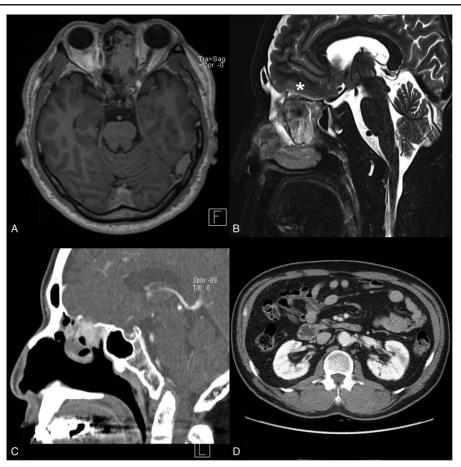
Radiological findings. Preoperative T1-weighted axial MRI with gadolinium enhancement (A) and T2-weighted sagittal MRI (B) demonstrated a heterogeneously enhanced mass in the paranasal sinus with invasion of the dura mater of the anterior skull base (asterisk). A bony destruction of the anterior skull base was also observed on sagittal CT scan (C). Note that enhanced abdominal CT scan (D) demonstrated no mass lesion in both the kidneys. CT = computed tomography, MRI = magnetic resonance imaging.
